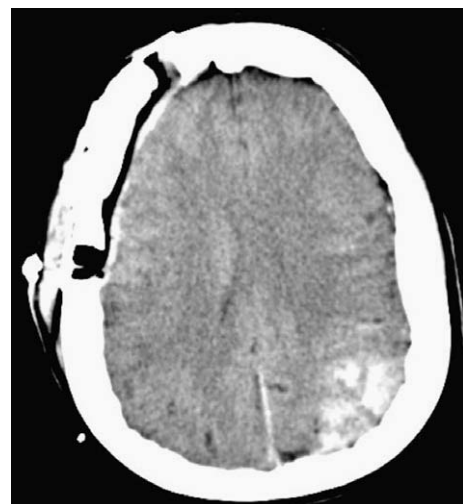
Postoperative day 1 axial CT scan without contrast enhancement showing blood in the left parietal meningioma.
